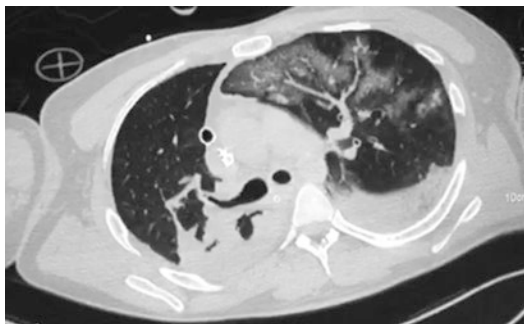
Thorax CT (second day of ECMO)
